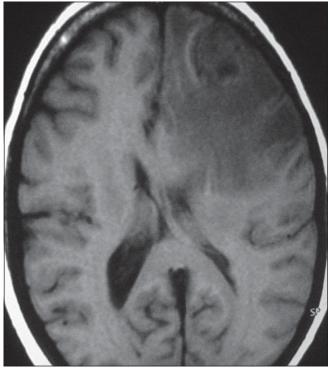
MRI Brain T1WI (axial view) showing isointense to hypo intense lesion in the left frontal lobe
